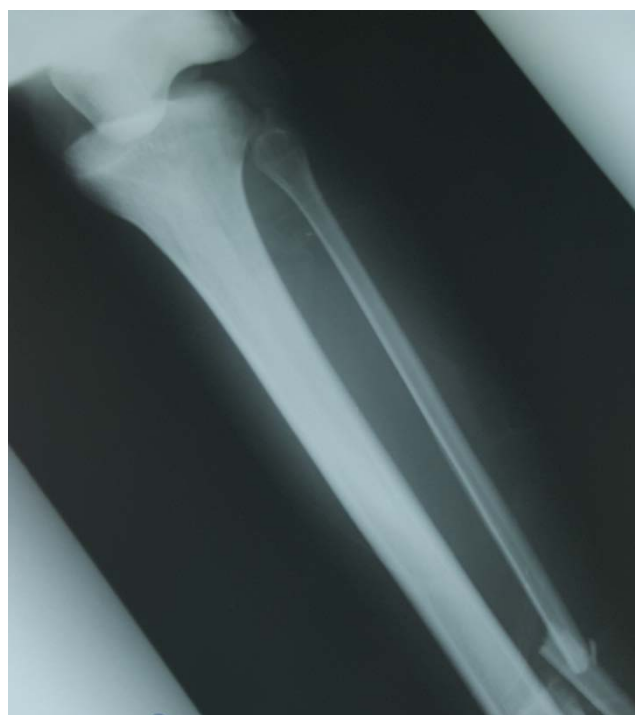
Radiography showing tibial shaft with knee dislocation.
